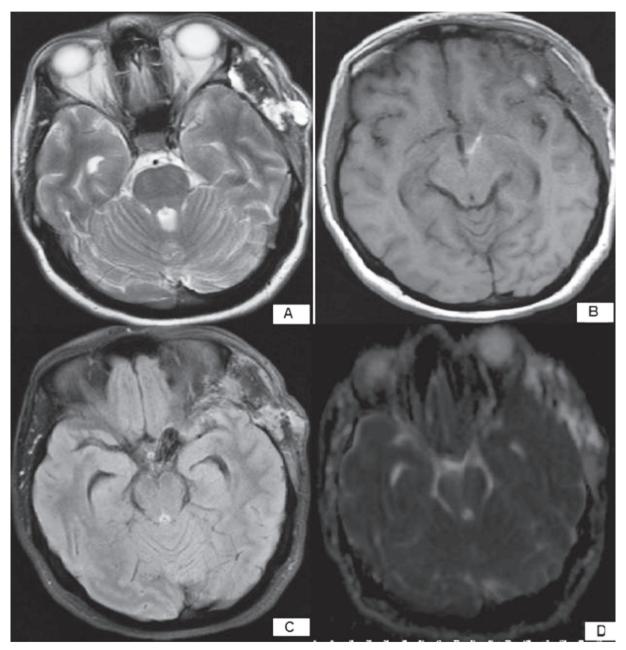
Cranial MRI that performed on the third postoperative day after the MGS of the opposite side clinical symptoms appeared. [A]: Axial sectioned T2-weighted MRI; [B]: Axial sectioned T1-weighted MRI; [C]: Axial sectioned T2-flair MRI; [D]: Axial section diffusion ADC; MRI shows no pathological findings that due to MGS.
